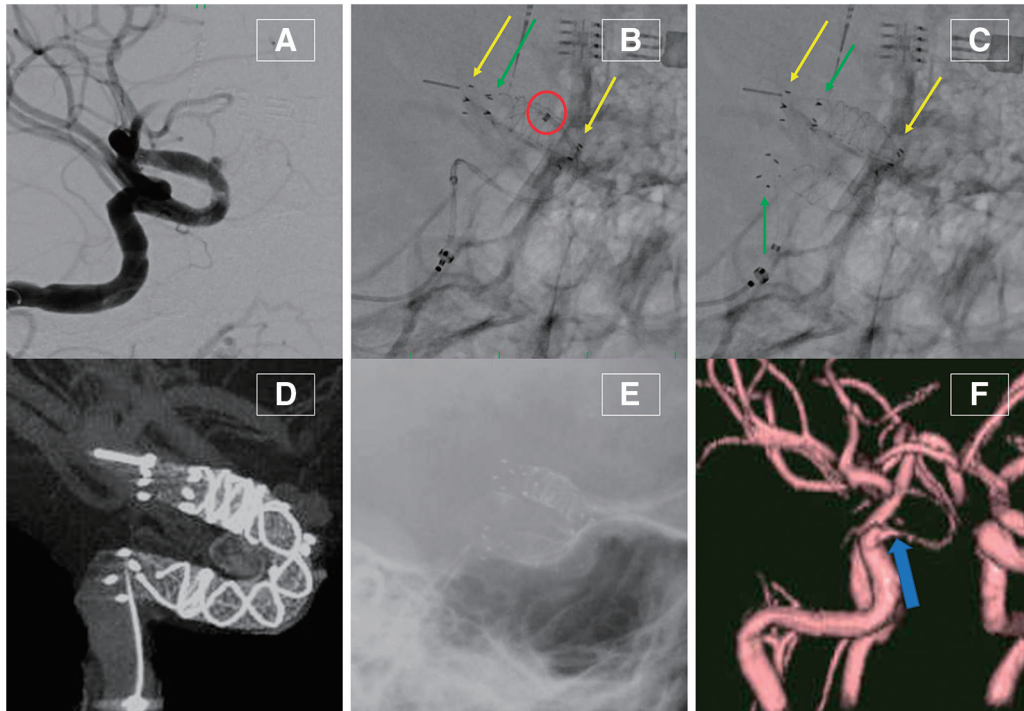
Second treatment using FRED. Angiogram in the working angle image before the second treatment (A). A 4.0-mm-diameter and 23-mm-long FRED was deployed in an overlapping fashion from the part (green arrow) just proximal to the distal edge of the first FRED stent. The yellow arrows show the distal and proximal flared ends of the first FRED, respectively. The red circle shows the tip of the microcatheter for the second FRED deployment (B). Lastly, the second FRED was deployed up to the proximal part of the carotid siphon. The yellow arrows show the distal and proximal flared ends of the second FRED, respectively (C). Full expansion of the FRED stents was confirmed using cone-beam CTA (D). Skull X-ray images 1 day after the treatment did not show any obvious migration or shortening of the FRED stents (E). The MRA 1 day after the treatment also demonstrated signal loss spanning the proximal part of the carotid siphon (blue arrow), indicating no obvious migration of the stents (F). FRED: flow-redirection endoluminal device
